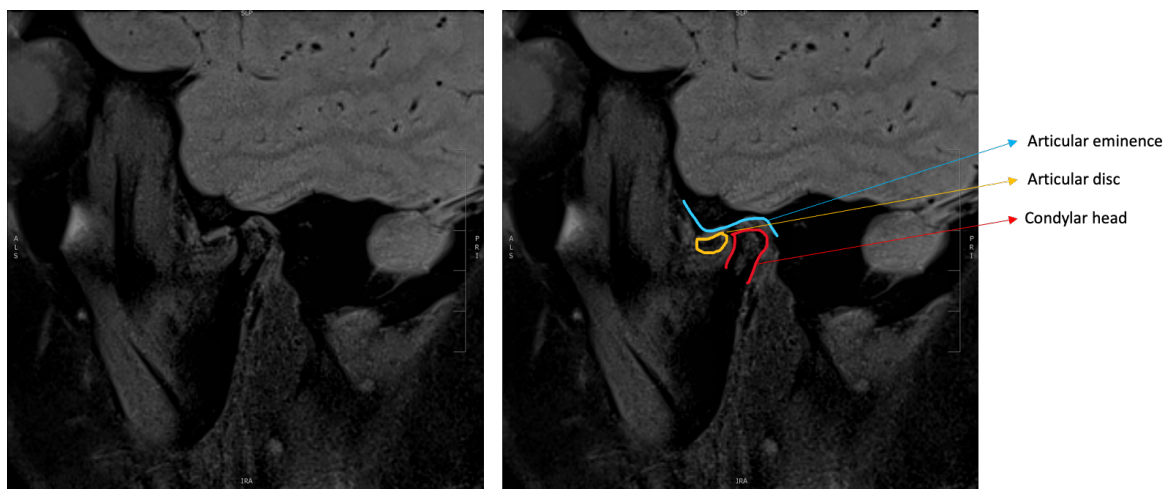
Sagittal MRI. Sagittal MRI demonstrating OA of the right TMJ with ADD on a closed mouth view. Note the flattening and anterior lipping of the condylar head.
